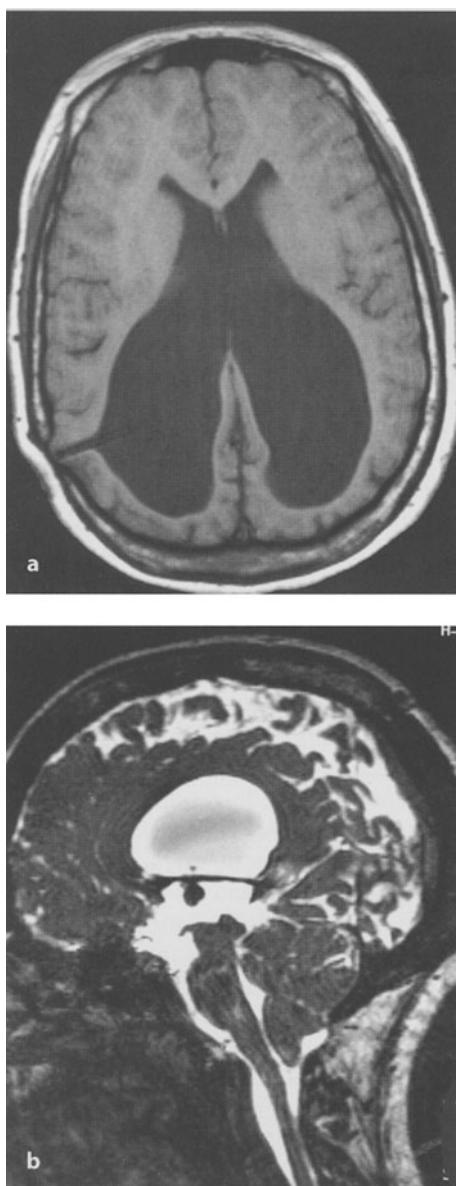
MRI scans of a 14-year-old girl with thoracic myelomeningocele and shunted hydrocephalus, who presented with symptoms indicative of shunt malfunction. a Axial T1-weighted MRI scan showing the typical ventricular configuration of patients with myelomeningocele-related hydrocephalus. Small frontal horns and large occipital horns are seen. The shunt catheter is seen in the right parietal region. b Sagittal CISS (constructive interference in the steady state) scan showing absence of high signal in the region of the aqueduct, indicating non-patency
